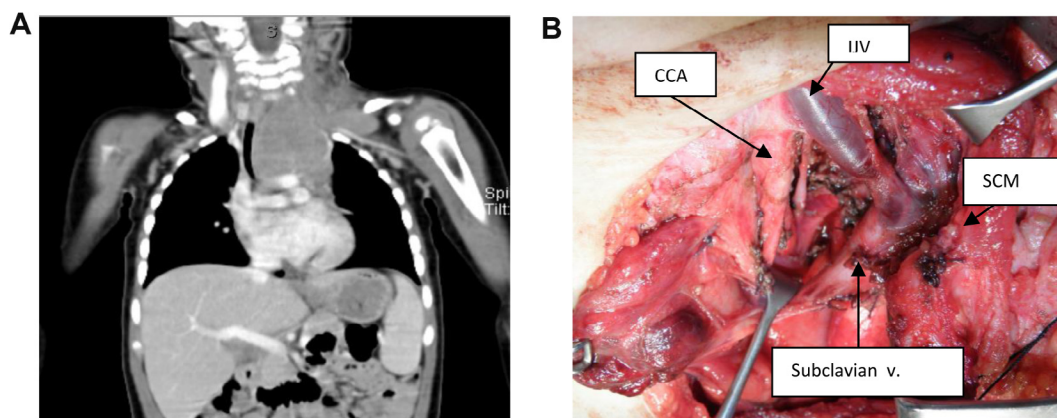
(a) CT, coronal view of mediastinal NB. (b) Intraoperative view of trapdoor approach IJV: Internal jugular vein CCA: Common carotid artery SCM: Sternocleidomastoid muscle.
